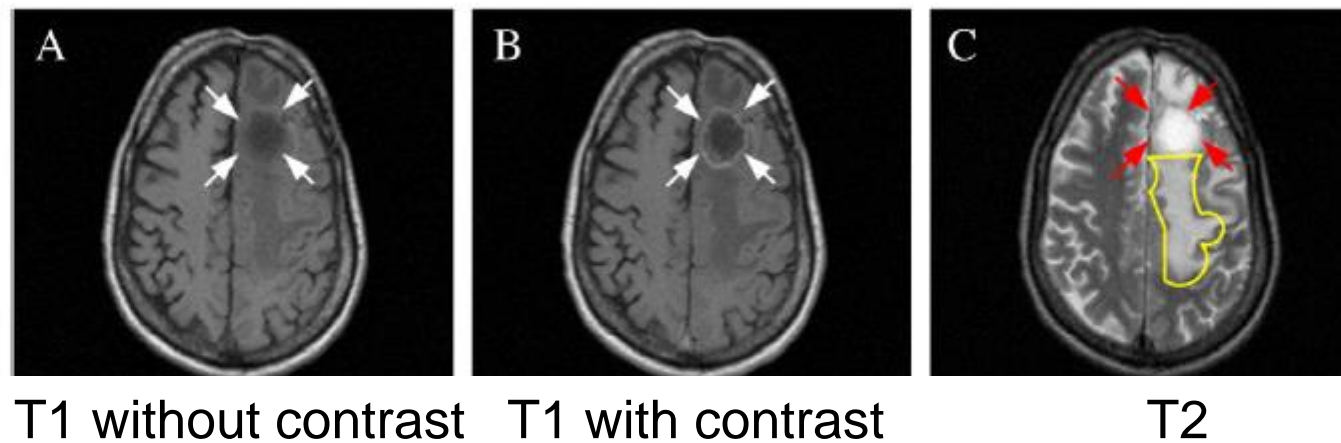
Appearance of astrocytoma tumor on three sequences. (A) Isointense tumor (diffused) on T1-weighted image. (B) Isointense, peripherally enhanced homogeneous tumor on postcontrast T1-weighted image. (C) The tumor is seen as a homogeneous, hyperintense mass on T2-weighted image (in red) as is the edema, which, however, is less bright (in yellow).
